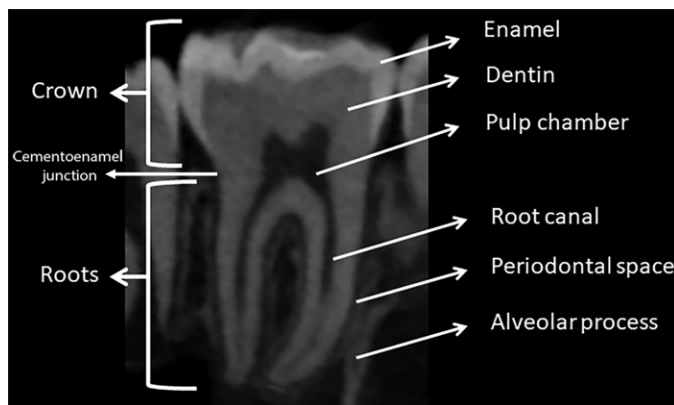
Tooth anatomy. Sagittal cone-beam CT image demonstrates the two main parts of the tooth and its layers, attached to the alveolar process.
